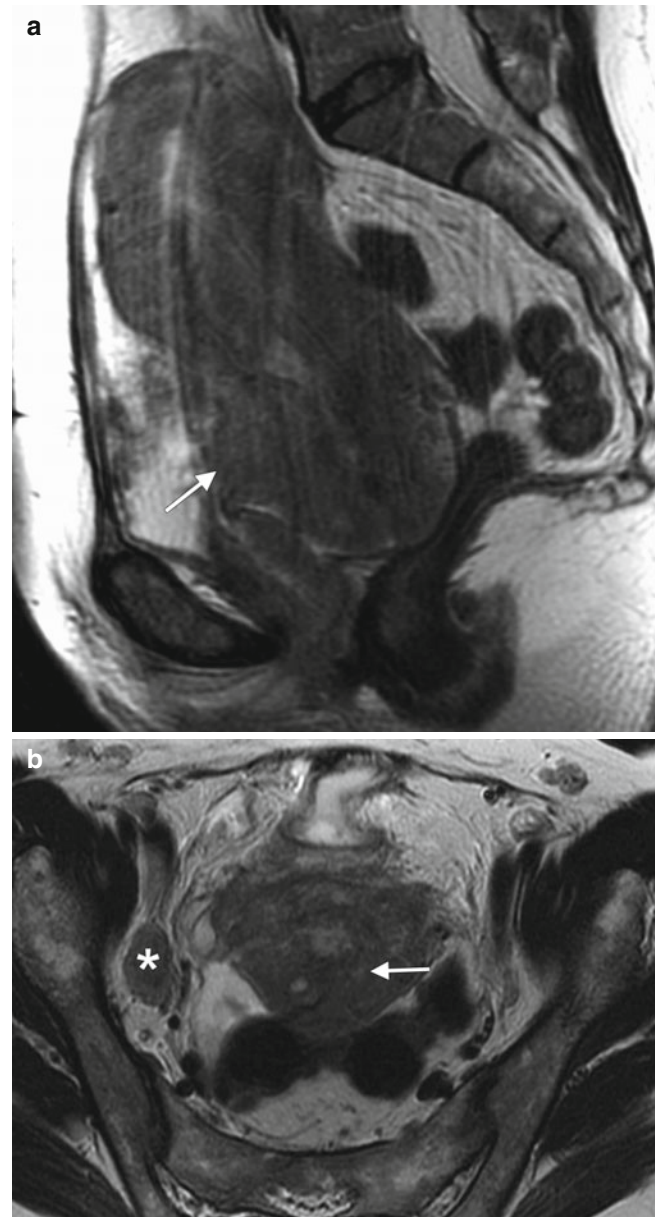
FIGO stage III endometrial cancer in a 49-year-old woman with menorrhagia. Sagittal (a) and axial (b) T2-weighted MR images and an axial, fat-suppressed T1-weighted image following intravenous gadolinium (c) demonstrate a heterogeneous endometrial mass (arrows) with extension beyond the uterine serosa and ovarian metastasis (asterisks). An axial T1-weighted MR image (d) shows a T1-hypointense lesion (arrowhead) suspicious for metastasis
